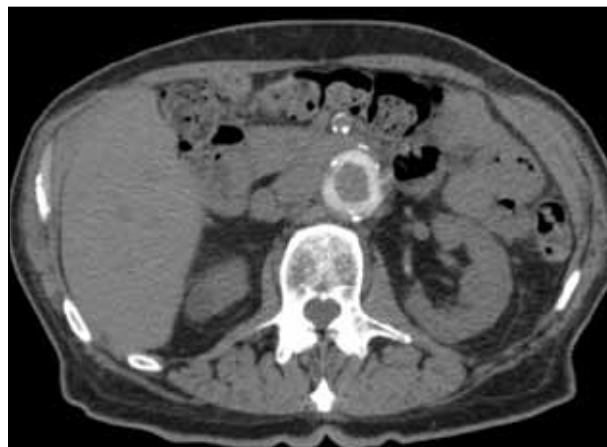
A noncontrast CT image reveals the Ovation Prime seal ring in the infrarenal neck at 1-month follow-up.
